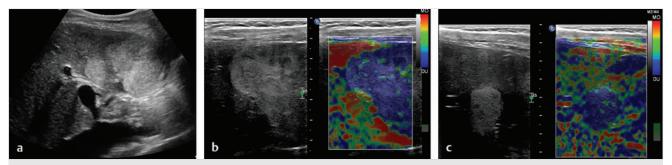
Strain elastography (SE) of a focal liver mass. (a) A baseline axial grayscale sonogram on a young asymptomatic woman shows two focal echogenic masses within a normal-looking liver. (b) SE is performed of the largest mass while watching the liver during normal quiet respiration. The large mass appears blue (stiff) relative to the softer liver (red/green). (c) Similarly the smaller echogenic mass is blue within the surrounding softer red/ green liver. These are proven hemangiomata on contrast-enhanced ultrasound imaging.
